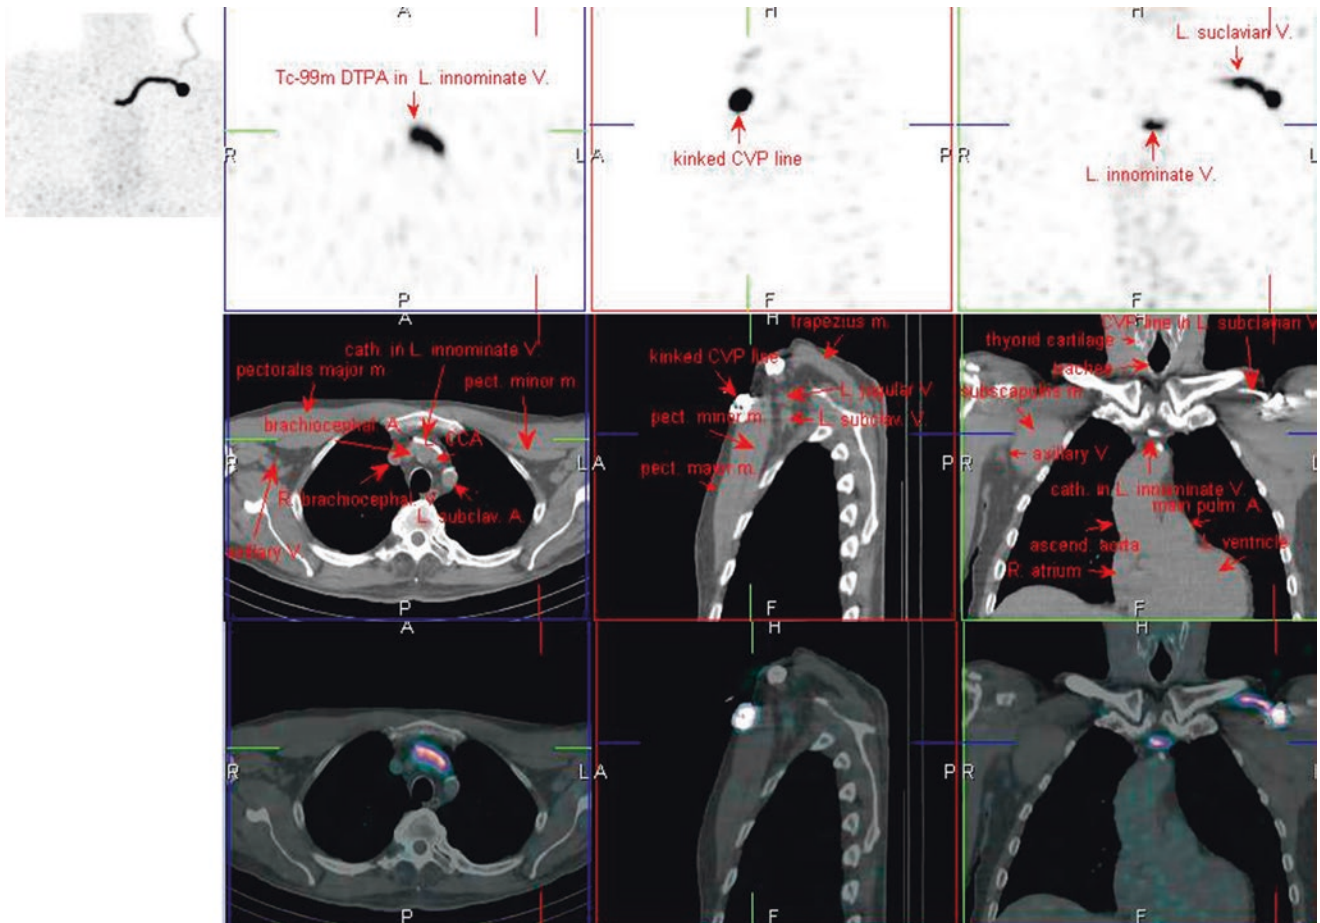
^{99m}Tc-DTPA SPECT/CT
